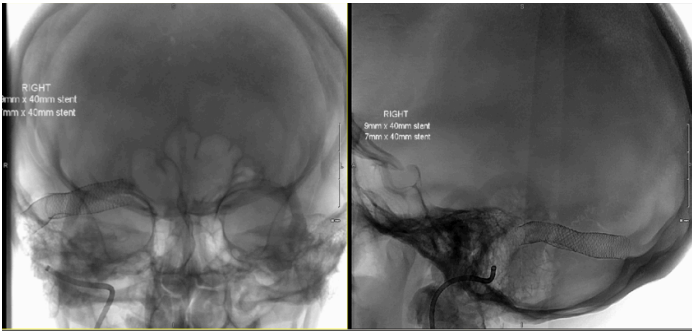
Crane X-Ray antero-posterior and lateral view showing placement of stents within the right transverse sinus.
